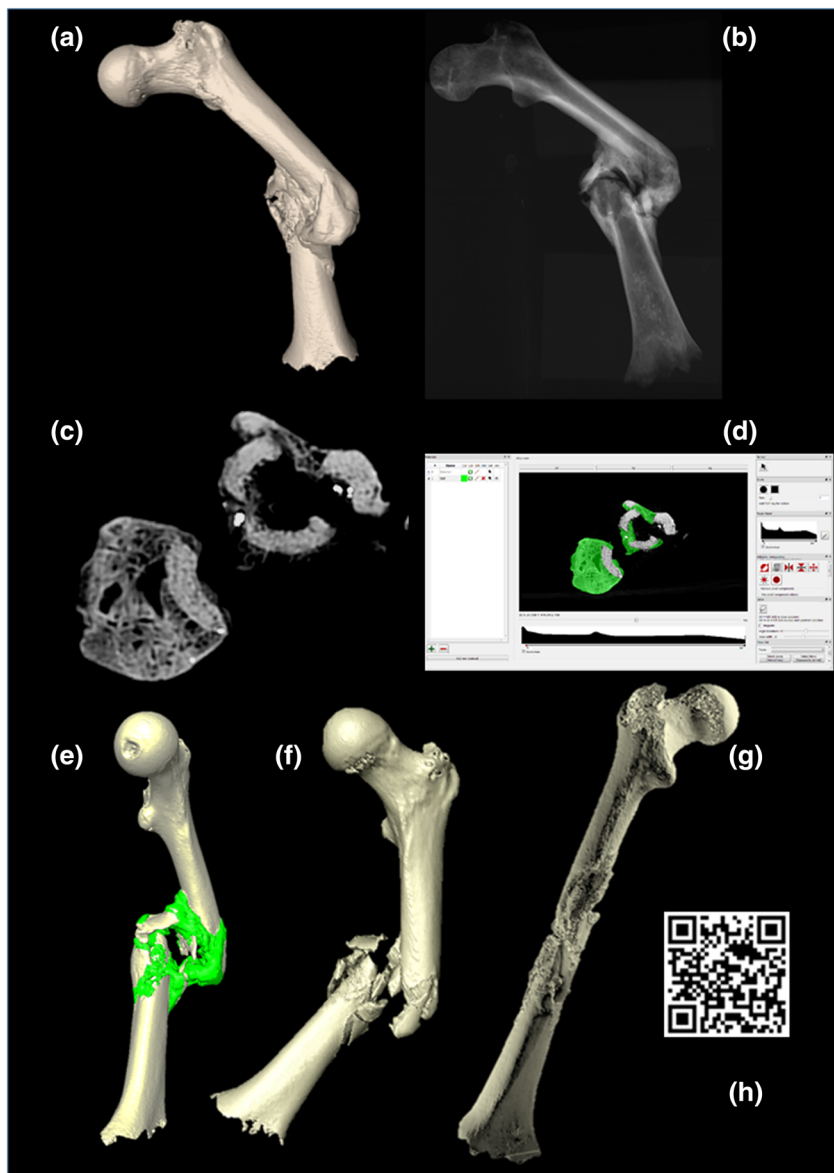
Comminuted femoral shaft fracture (Kaliningrad, Russian Federation, 1812). (a) Morphological aspect showing a partial healing in bad position. (b) Plain X-ray confirming the fracturing of the femoral diaphysis into several fragments. (c) Computed tomography (CT) scan, axial slice, revealing metallic artefacts embedded in the callus tissue. (d) TIVMI software interface showing the segmentation of callus tissue from cortical bone of femoral diaphysis. (e and f) Three-dimensional (3D) reconstructions showing the fracture area with and without callus tissue (green). (g) 3D reconstruction of the pretraumatic state. (h) QR code for video of the traumatic event reconstruction (palaeo-ballistic) [Colour figure can be viewed at wileyonlinelibrary.com]
